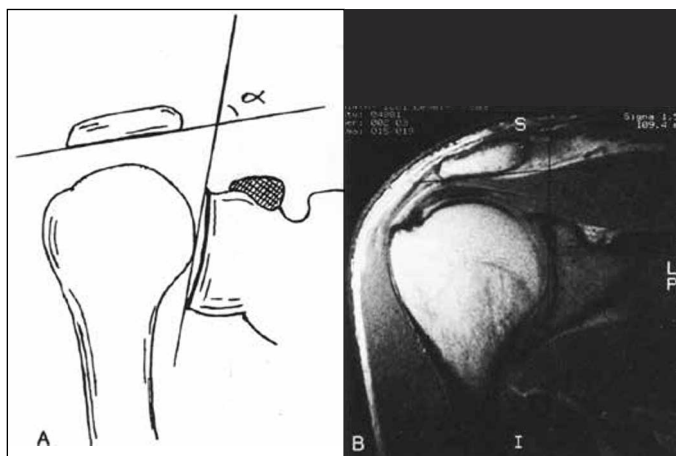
Relationship between the angle of lateral tilt of the acromion and rotator cuff injury in MRI⁽⁹⁾.
